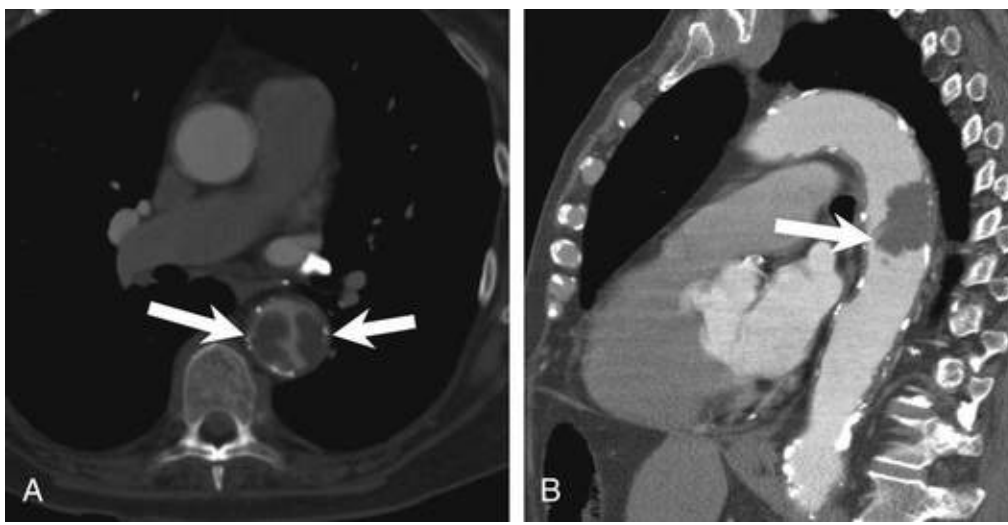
Intimal sarcoma of the descending thoracic aorta in a 70-year-old woman. Contrast-enhanced computed tomography shows an irregular low-density mass (*arrows*) partially filling the aortic lumen in the axial (A) and sagittal (B) planes. Extensive atherosclerotic calcifications appear throughout the aortic wall. (From Restrepo CS, Betancourt SL, Martinez-Jimenez S, et al. Aortic tumors. *Semin Ultrasound CT MR* 2012;33:265.)
